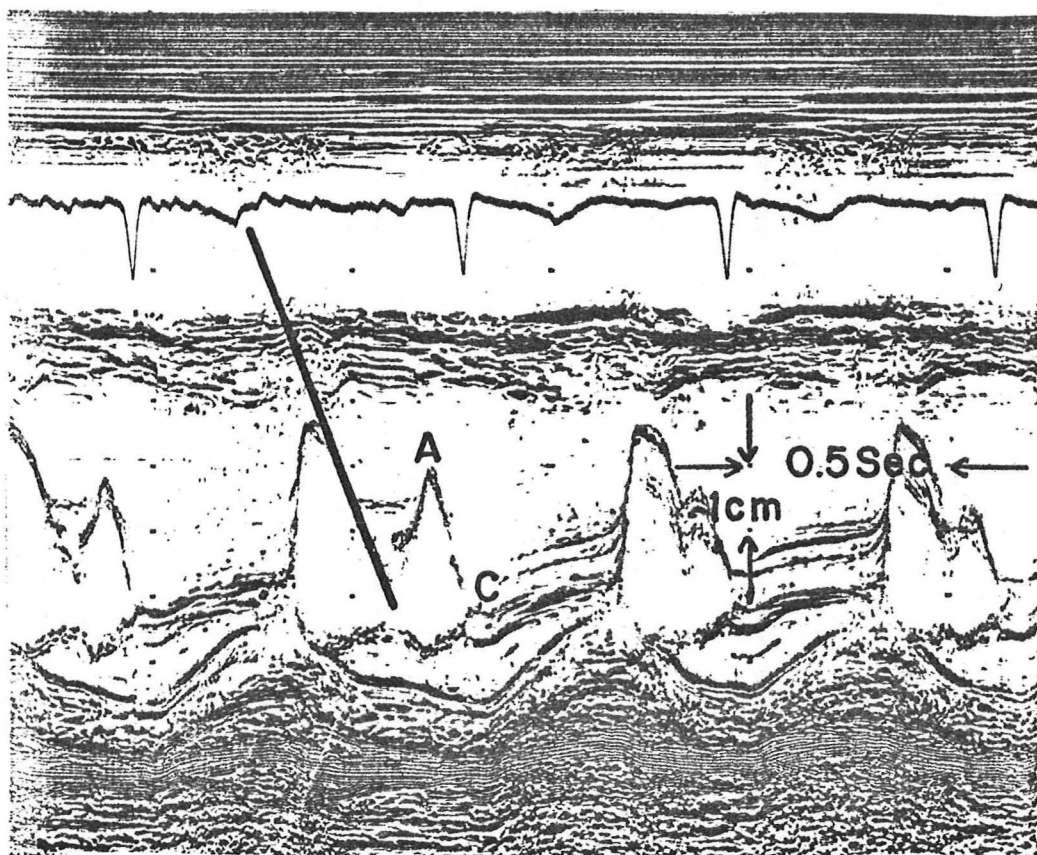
A normal echocardiogram of the mitral valve showing both leaflets. The heavy line represents the early diastolic closing velocity or E to F slope. Letters A and C annotate points of change of leaflet motion.
